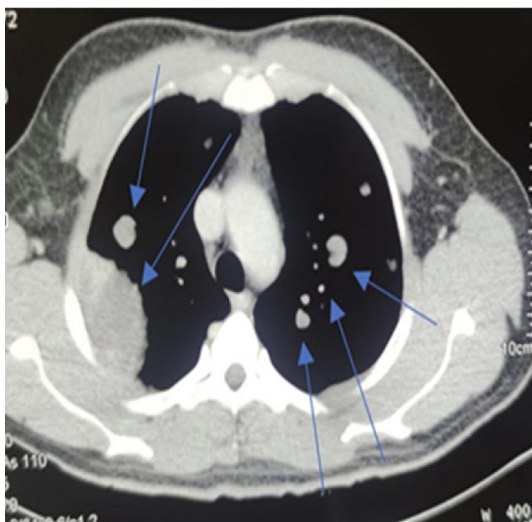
(A) Chest X-ray showed multiple masses (cannonball metastases). (B) CT chest with contrast showing multiple lung masses.
